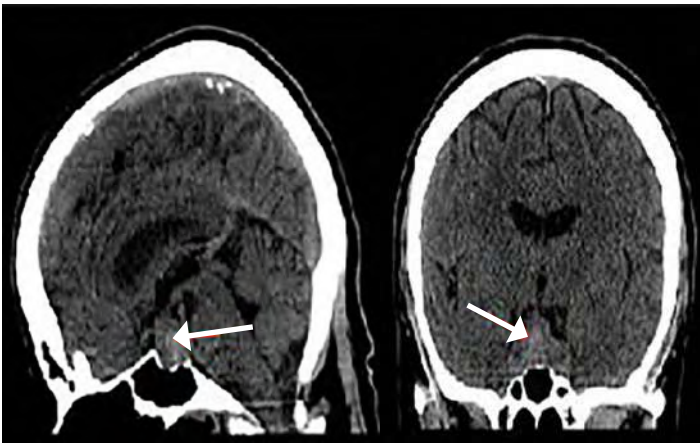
Computed tomography of the head without contrast demonstrating enlarged pituitary gland with increased density consistent with hemorrhage (arrows).
